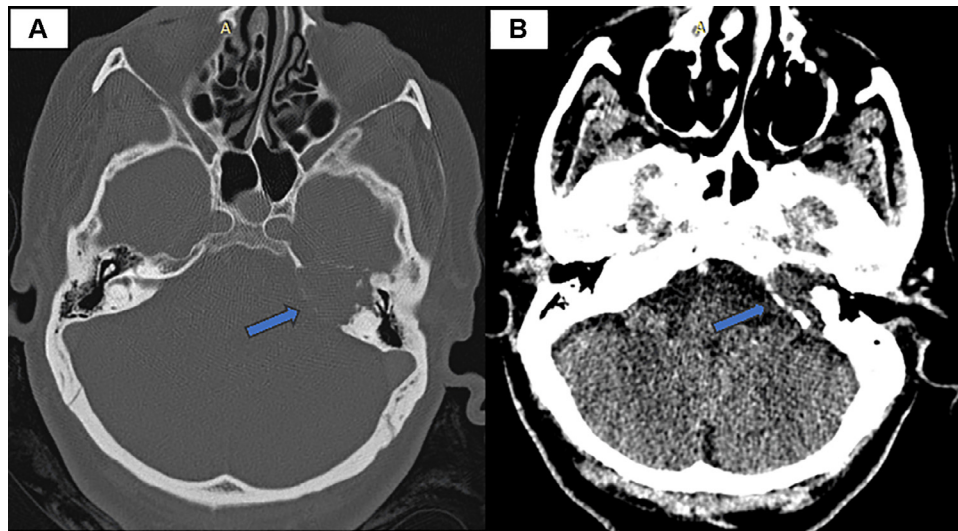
(A) Axial CT scan (Bone window) showing an expansile soft tissue mass the left petrous apex (Blue arrow). (B) Axial CT scan (Soft tissue window) Showing a hypodense soft tissue mass of the left petrous apex with no enhancement after contrast administration (Blue arrow).
